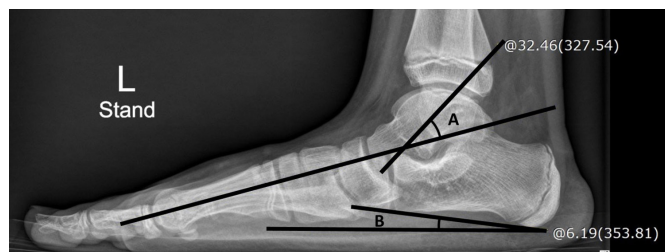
Radiographic measurements in plain lateral radiographs. A, lateral tarso-first metatarsal angle; B, calcaneal inclination angle.
